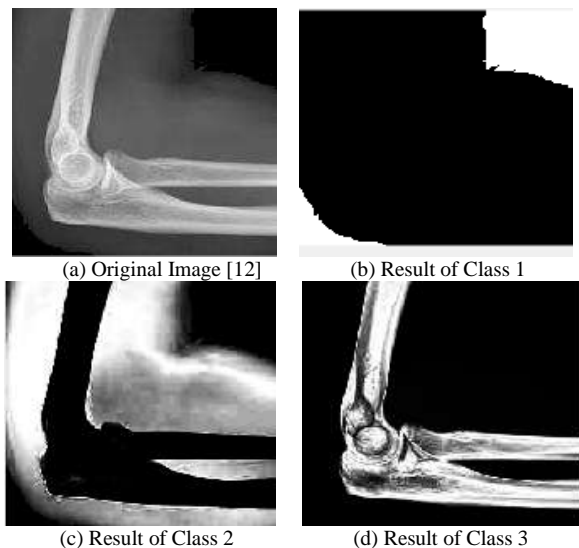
Probabilistic Segmentation for Three Regions. (a) Indicates the Original Elbow X-ray Image. (b) Indicates the Result for Segmentation of First Class which Highlights the Pixels of Background. (c) Shows the Result of Second Class Segmentation in which the Pixels Involved in Flash are highlighted. (d) shows the region of interest as a result of third class Segmentation in which the Bone in the X-ray Image is Highlighted.
